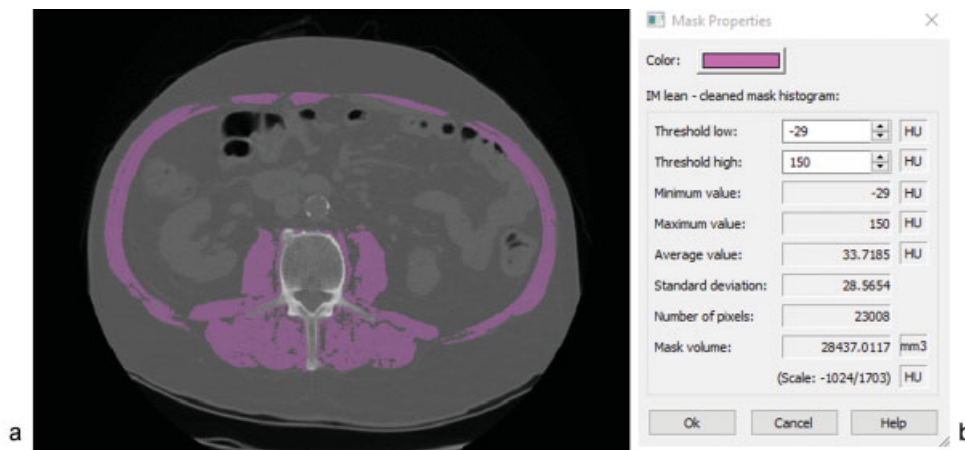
A 65-year-old woman presents for sarcopenia evaluation. (a) Computed tomography image at L3 shows segmented psoas, paraspinus, and abdominal muscles. (b) Using – 29 to + 150 HU threshold, the muscle measures 28.4 cm². The skeletal muscle index (SMI) = cross-sectional area (CSA)/ht² = 113.6/2.3 = 49.4 cm²/m². Based on the SMI threshold for women (< 38.5 cm²/m²), she does not meet the diagnostic criterion for sarcopenia.
